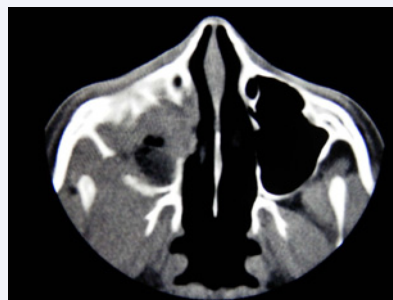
Computed Tomography (CT) scan of the paranasal sinuses shows mucosal thickening and soft tissue density in right maxillary sinus with lateral wall destruction.
